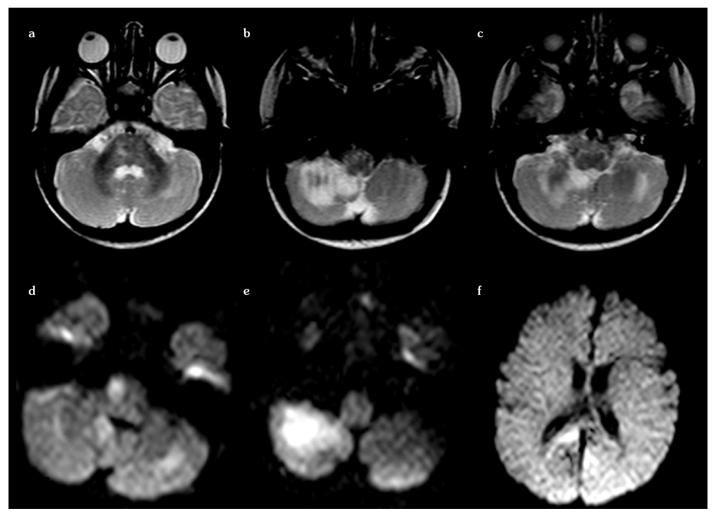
a, f. Axial T2-weighted images at the level of the cerebellum and brain stem (a-c) show hyperintense signal changes in the bilateral cerebellar hemispheres, which is predominant on the right and in the pons, consistent with infarction. Diffusion-weighted images (b=1000) (d, e) reflect these changes as restricted diffusion. Besides, another focal area of infarction is demonstrated on the right side of the splenium of the corpus callosum (f) on diffusion-weighted image, which is not appreciated on T2-weighted images
